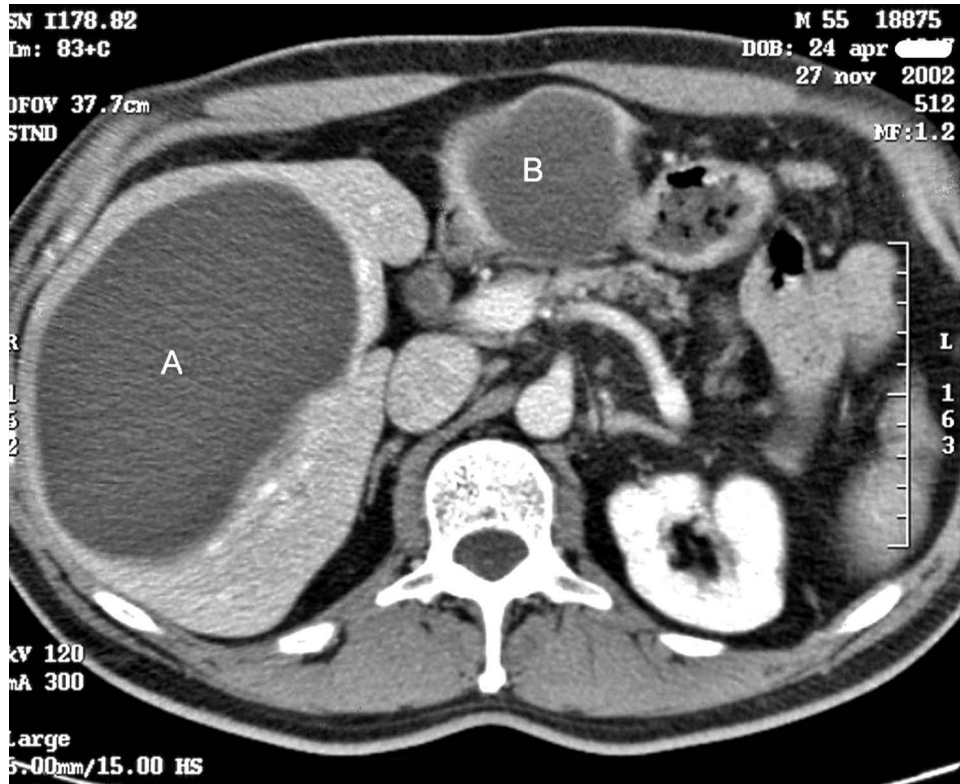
Computed tomography examination revealed cystic lesions of the liver. A, large cyst in the right lobe; B, cyst in the left lobe of the liver.
